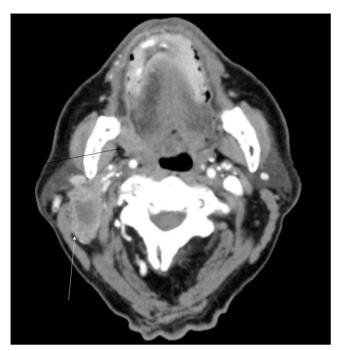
Axial contrast-enhanced CT showing a right retromolar trigone tumour (black arrow) with an associated necrotic level 2 node (white arrow).
